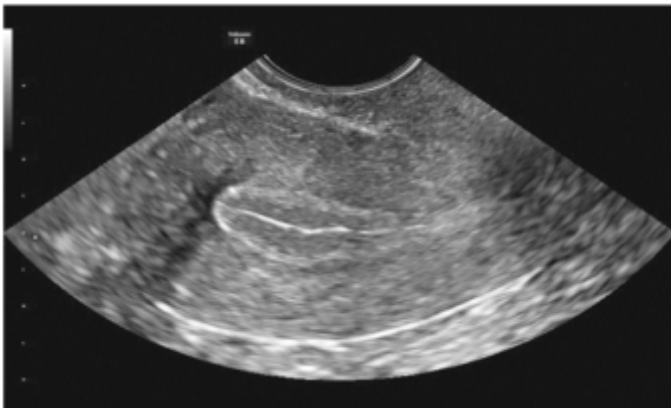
B mode ultrasound image of uterus in midsagittal plane showing triple layered endometrium with internal echogenicities between its layers, making it grade A endometrium.
